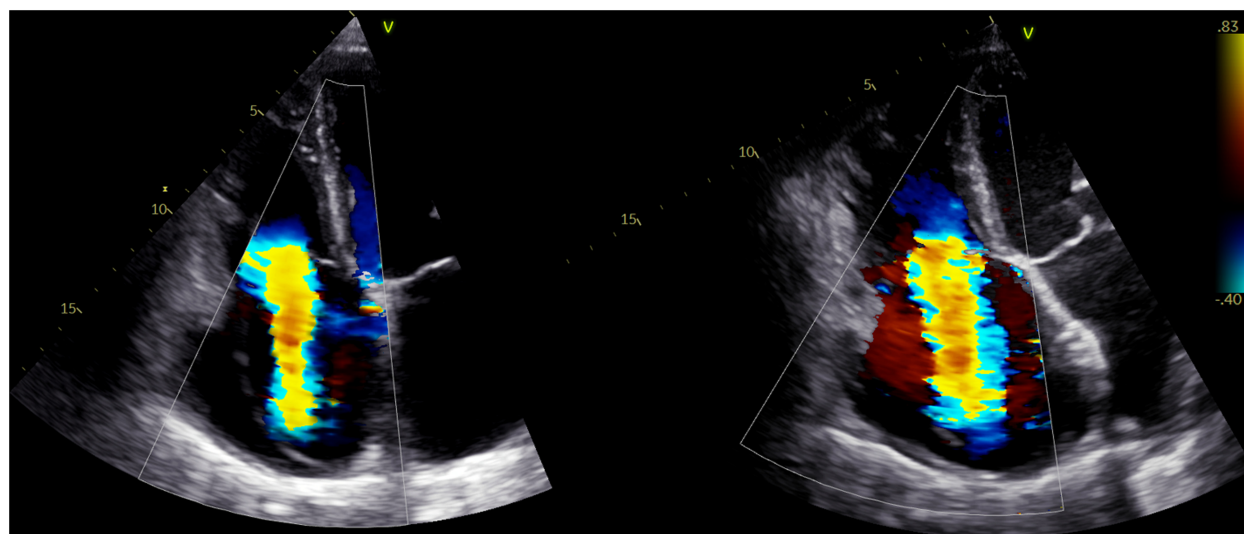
Progression of tricuspid regurgitation. In the left panel, the colour Doppler data show severe tricuspid regurgitation in an asymptomatic patient. The dimensions of the right ventricle are mildly increased and the systolic function is preserved. After 2 years of follow-up, the patient presents with severe heart failure symptoms (including ascites) despite high doses of diuretics. The right panel shows torrential tricuspid regurgitation, a severely dilated right ventricle, leftward deviation of the interatrial septum, and severely impaired right ventricular systolic function.
